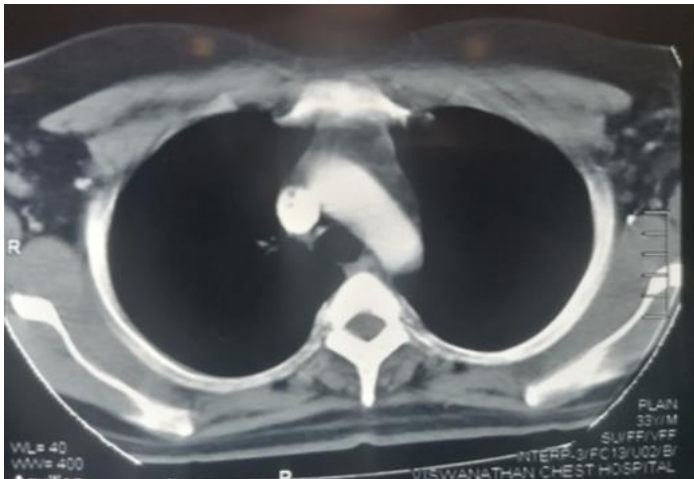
Computed Tomography (CT) of the chest shows complete resolution of anterior chest wall swelling.
